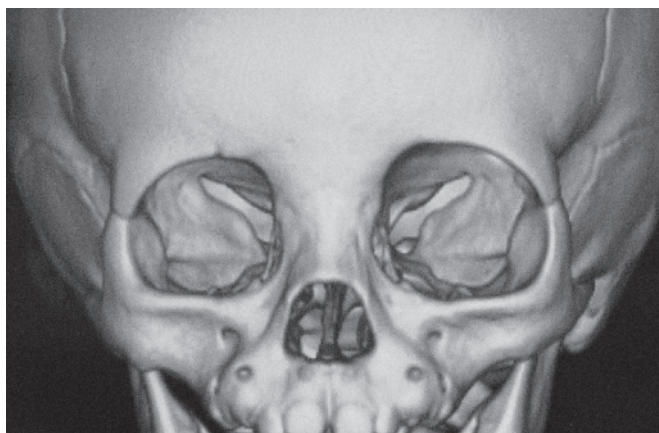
Right microphthalmic orbit. Three-dimensional computed tomography (CT) reconstruction demonstrates a hypoplastic right orbit with microphthalmia. (Courtesy of Bobby S. Korn, MD, PhD.)
